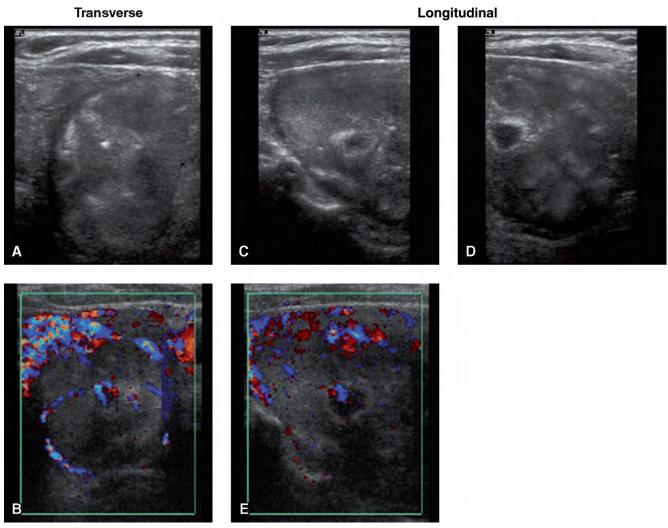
Ultrasound of follicular adenoma in the left lobe. A, Transverse, 27 x 39 mm. B, Color Doppler, transverse. C, Upper part, longitudinal. D, Lower part, longitudinal. E, Color Doppler, longitudinal.
